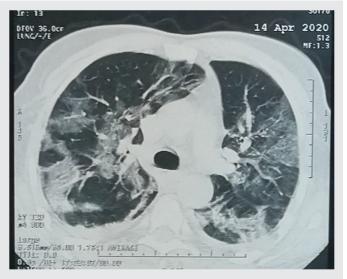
Thoracic CT scan with ground glass opacities and crazy paving classified as CO-RADS 5.
